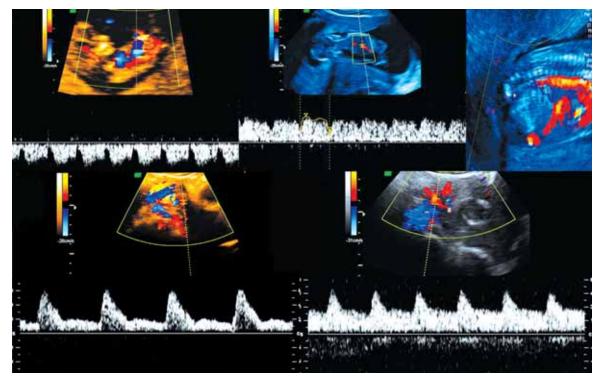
Transabdominal color Doppler evaluation of the fetus at the first trimester. Above normal flow at the ductus venosus with a positive wave. Blood flow at aortic arch and descending aorta. Fetal circulation can be imaged easily even at the first trimester. Uterine artery color Doppler evaluation in the first trimester. Lower left picture shows uterine artery with notching and lower right picture shows uterine artery with normal flow at diastole
